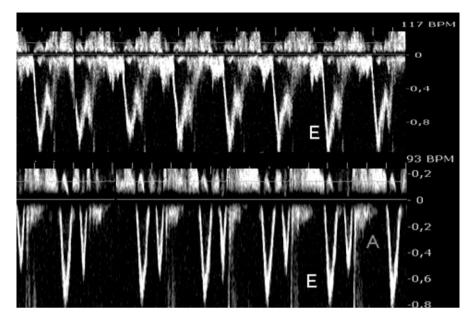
Echocardiographic evaluation of diastolic function. The figure shows the improvement in diastolic function after heart rate reduction from 117 to 93 beats per minute with esmolol
